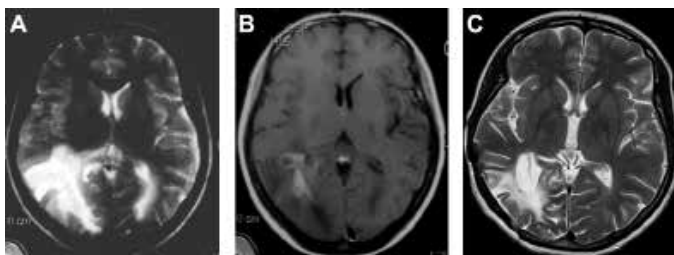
In cranial magnetic resonance imaging, A) Axial T2W, B) Contrast-enhanced T1W images reveal a large solitary right parietal periventricular white matter lesion with conspicuous enhancement involving the corpus callosum and left forceps major, C) Follow-up magnetic resonance imaging after treatment demonstrates near-complete resolution of the periventricular hyperintense lesion; contrast-enhancement in that area had disappeared (not shown)
